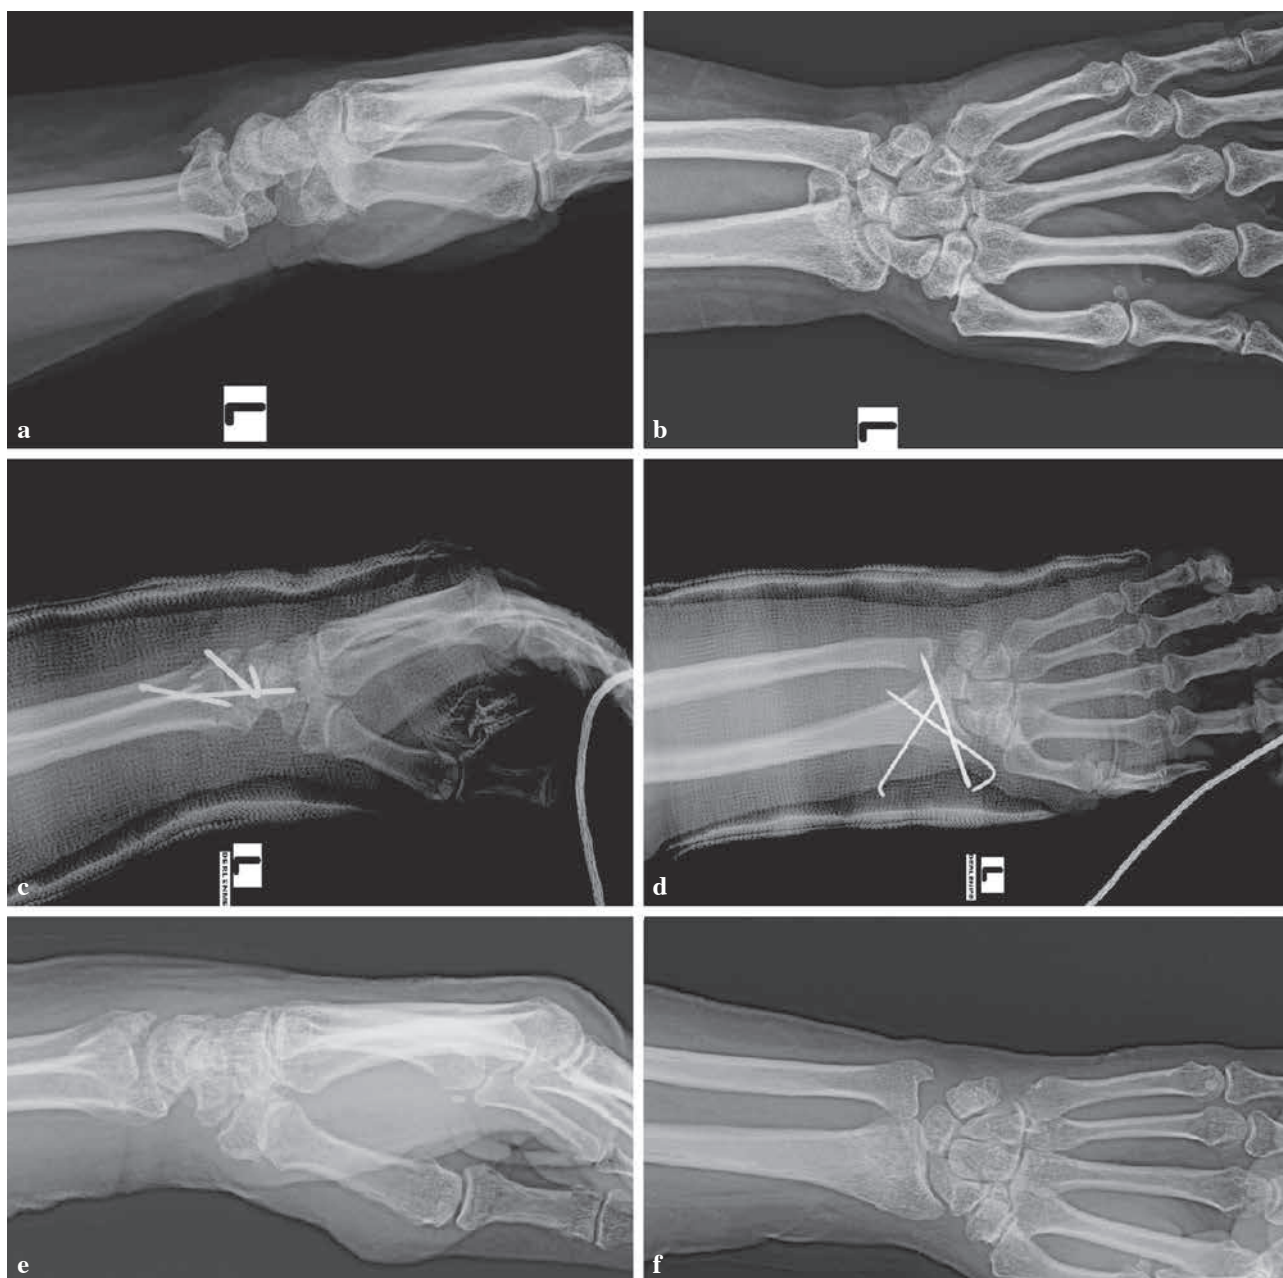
PKW surgical method a) preoperative lateral x-ray, b) preoperative anterior-posterior x-ray, c) early postoperative lateral x-ray, d) early postoperative anterior-posterior x-ray, e) 12 week follow up postoperative lateral x-ray, f) 12 week follow up postoperative anterior-posterior x-ray.
